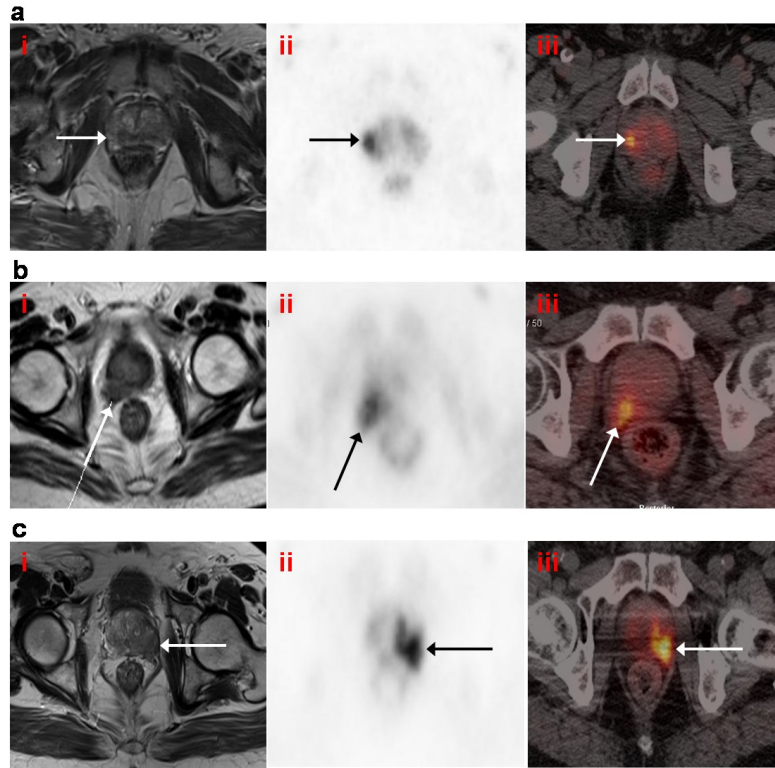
T2 weighted MRI (i), Axial $[^{11}\text{C}]$ choline PET (ii) and fused PET/CT (iii) showing uptake in the prostate and Seminal vesicles.
